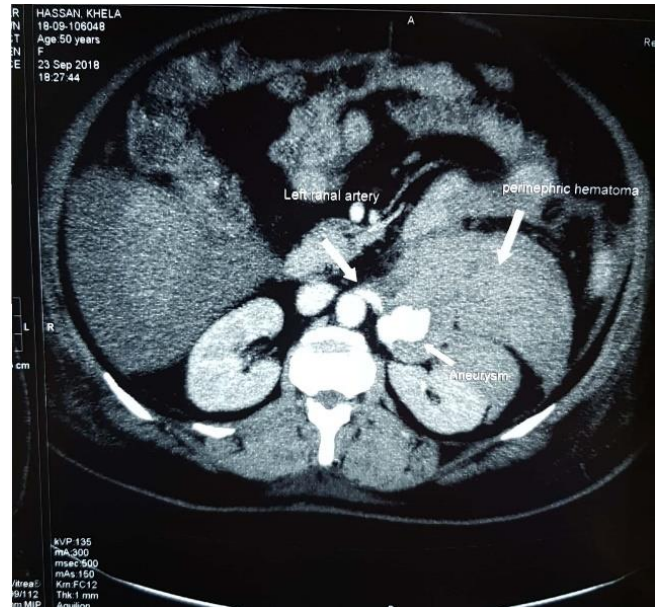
A transverse view of the CT - Scan of the Abdomen shows the formation of the perinephric hematoma in close proximity of the renal artery.
